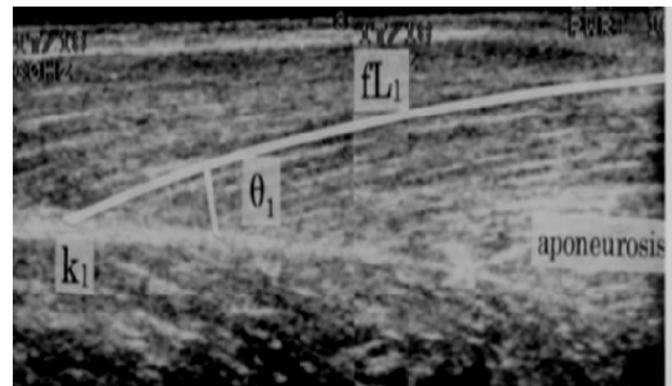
Ultrasonographic images of the vastus lateralis muscle (FL: fascicle length; θ : fascicle angle (the angle between fascicles and deep aponeuroses); and K: fascicle-aponeurosis connection)
